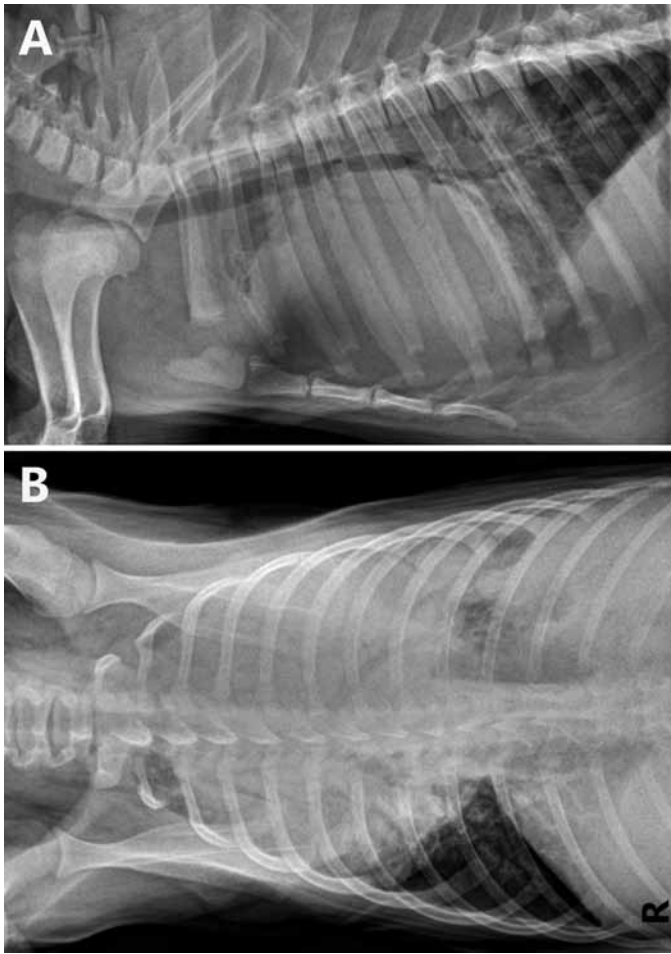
Radiographs taken before FDG-PET-CT scan. (A) Lateral thoracic view demonstrating an obscured cardiac silhouette and narrow, elevated trachea. (B) Ventrodorsal thoracic radiograph, demonstrating increased opacity throughout the thoracic cavity except for the right caudal lung lobe.
